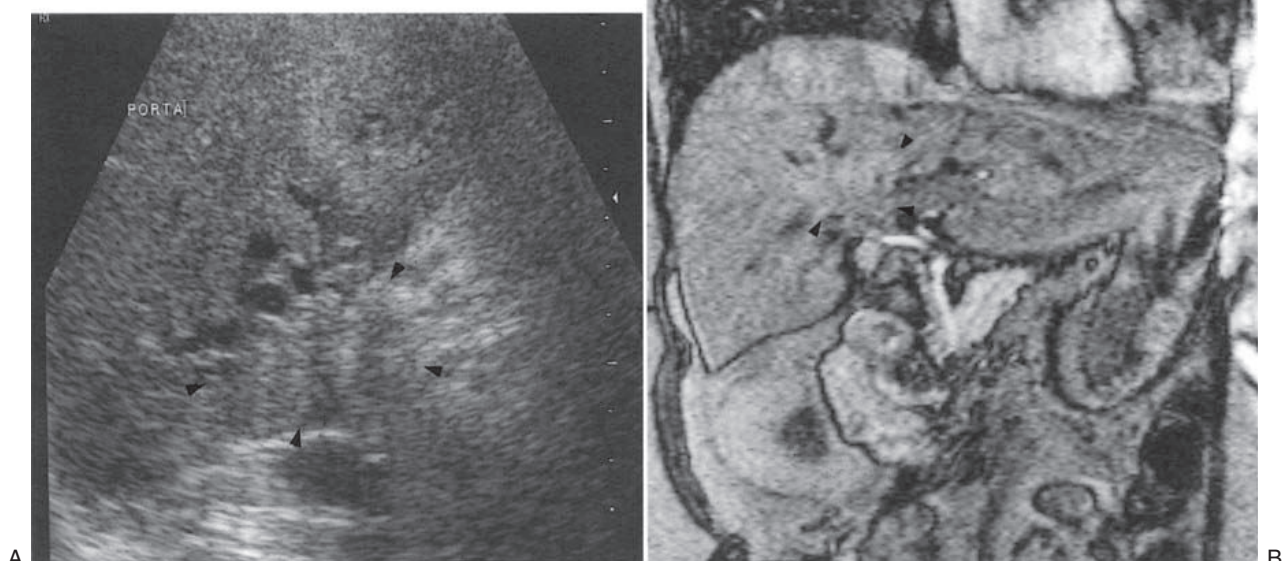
Cholangiocarcinoma. (A) Irregular mass at the porta, causing biliary obstruction—a Klatskin tumour. (B) MRI of the same patient, confirming the mass at the porta.
